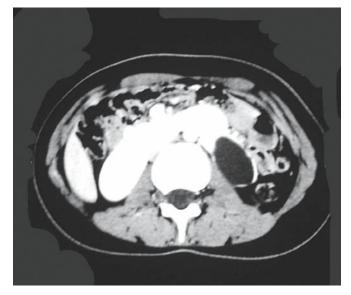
A CT scan shows a horseshoe kidney with a very thick isthmus and left moiety UPJ obstruction
